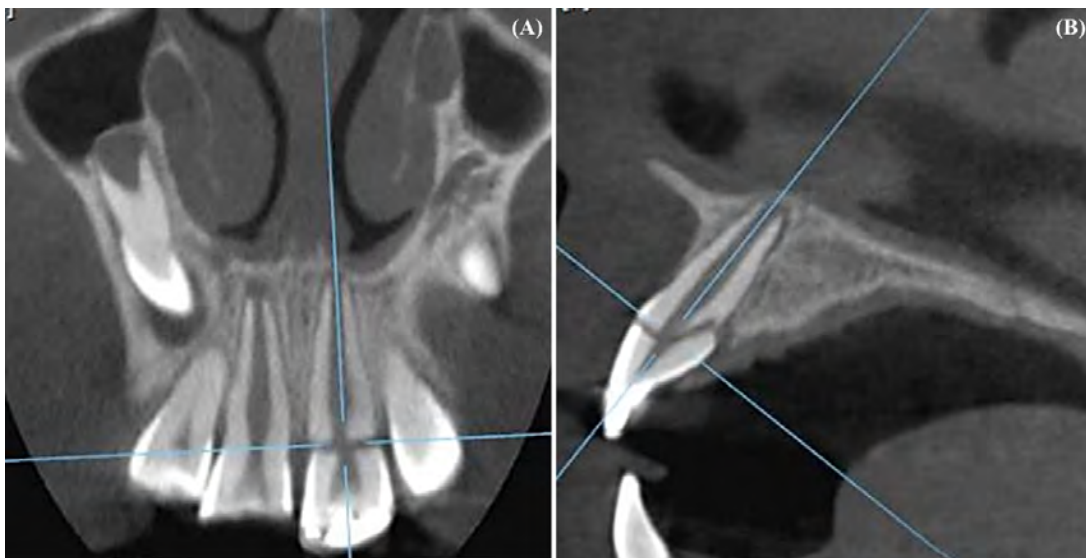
Image by CBCT obtained in the first dental appointment at the Dental Trauma Clinics at FORP/USP. Note in figure (A), in tooth 11 fracture of enamel and dentin and incomplete rhizogenesis. In (B), in tooth 21, a horizontal radiolucent image is noted at the cervical level, confirming the clinical suspicion of horizontal fracture of the crown root
